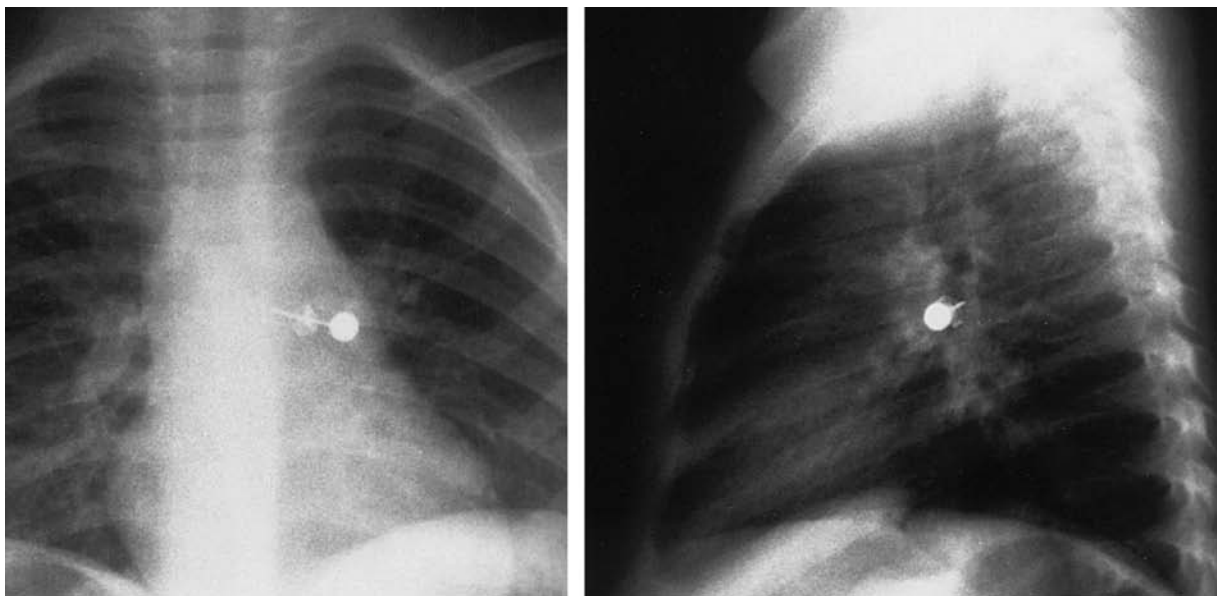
Two-view chest radiograph demonstrating aspirated radiopaque foreign body—an earring—located in the left bronchus.
